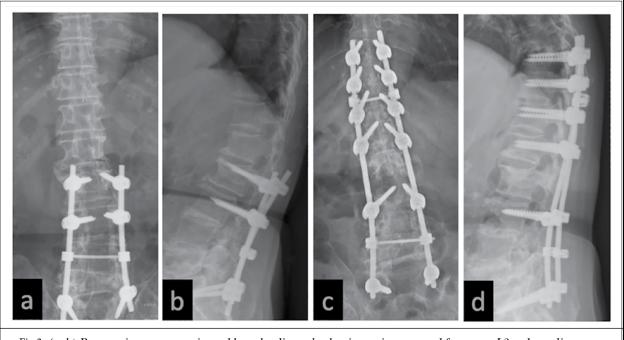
(a, b) Preoperative anteroposterior and lateral radiographs showing an instrumented fracture at L2 and an adjacent vertebral fracture at L1. (c, d) Plain films obtained postoperatively showing extension instrumentation to T11.
